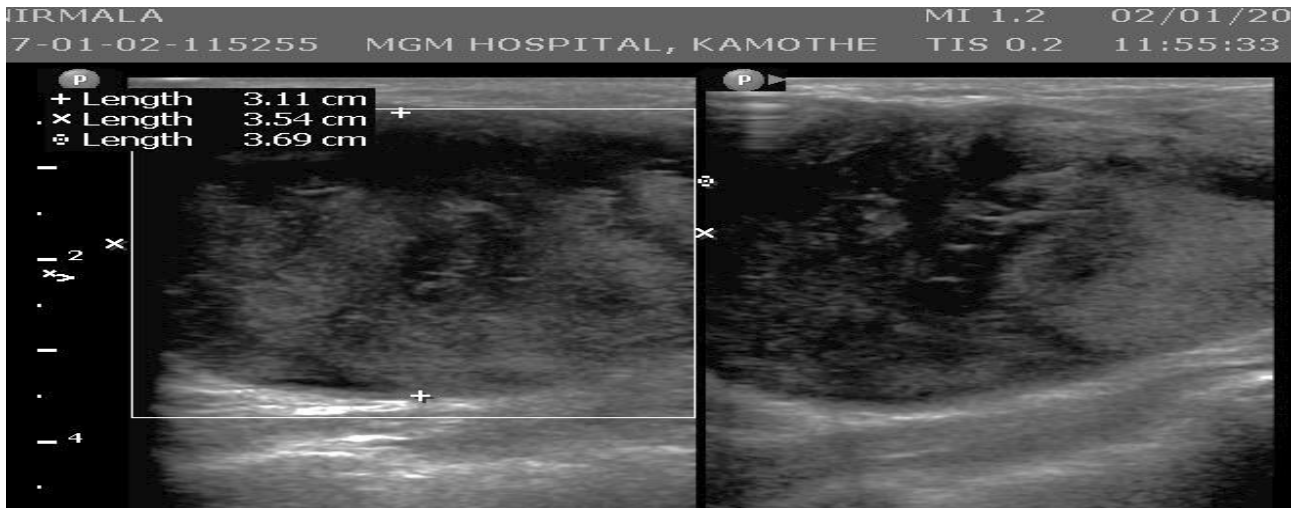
B. Phyllodes tumour. Ultrasound image showing heterogeneously hypoechoic mass.
